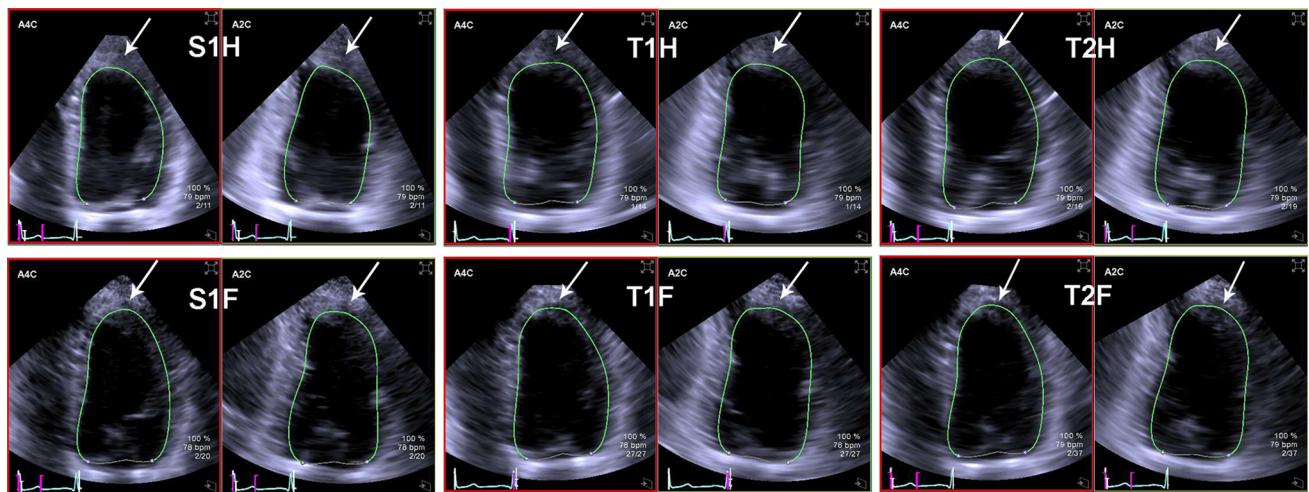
The near-field artefact (white arrows) and automated left ventricular contour in the multiplanar reconstruction views of the 3D datasets acquired by the six imaging modes. A4C apical 4 chamber view, A2C apical 2 chamber view; other abbreviations as in Fig. 2
